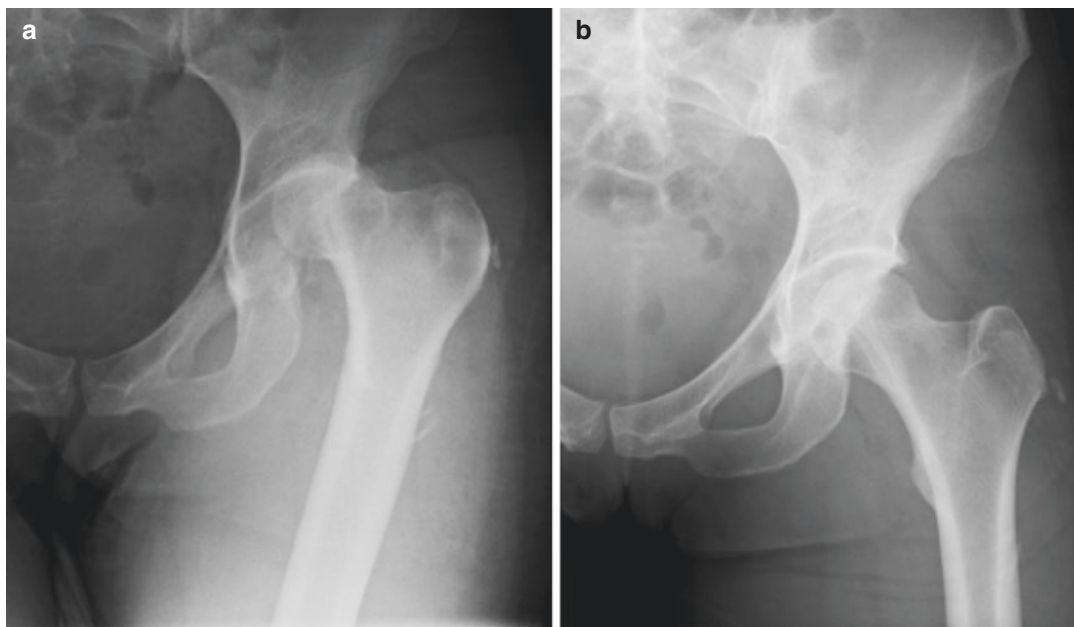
(a) AP radiograph of a hip showing posterior hip dislocation. (b) AP radiograph after reduction showing an incongruent joint with a slightly increased joint space
